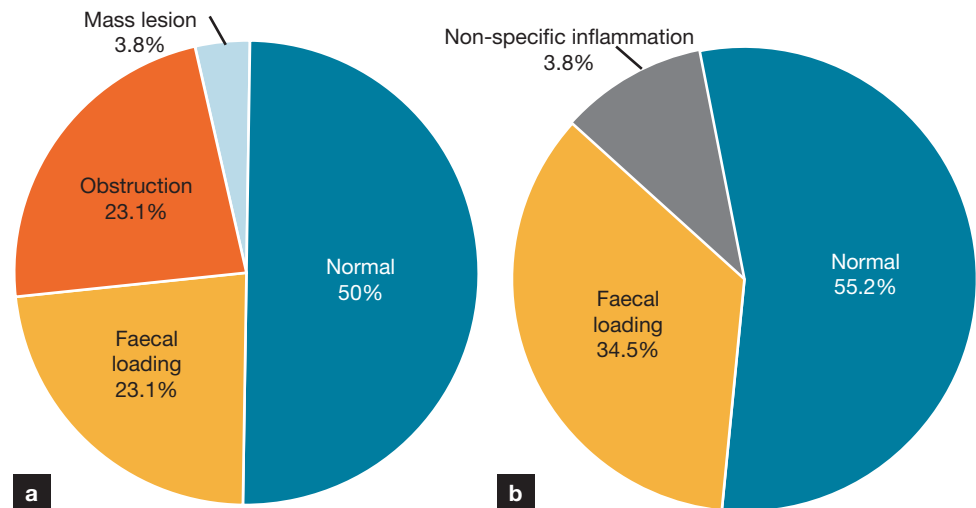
a. Indicated abdominal X-rays and (b) non-indicated abdominal X-rays.
